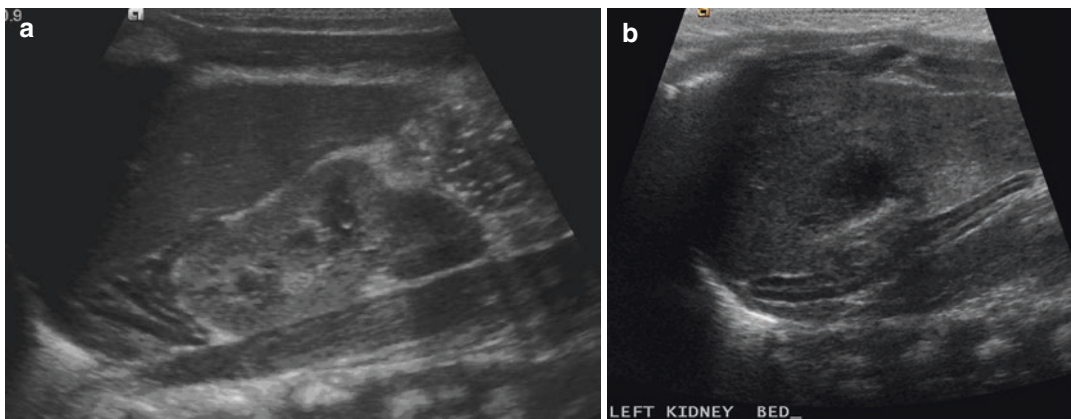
Normal adrenal ultrasound: (a) Note hypoechoic cortex and hyperechoic medulla. Note the lack of a fine, coiled cerebriform appearance. (b) Ultrasound of renal bed demonstrates ‘lying down adrenal,’ which is demonstrated with agenesis of the kidney
